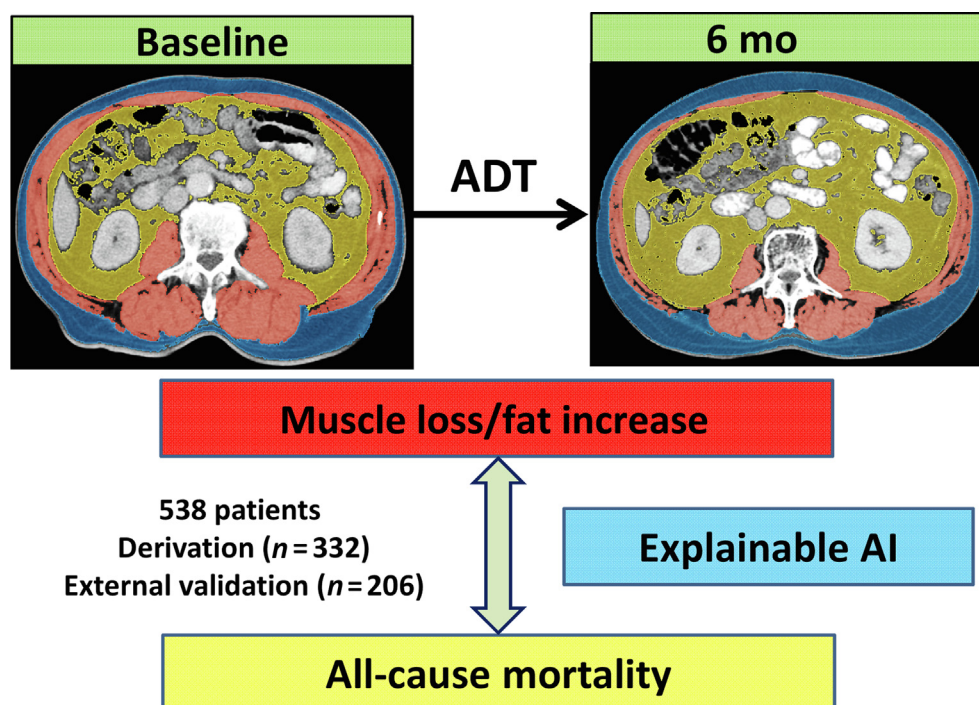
Utilization of explainable AI to explore the threshold of body composition change for all-cause mortality during androgen deprivation therapy. Body composition was assessed on a transversal computed tomography slice at the level of L3. ADT = androgen deprivation therapy; AI = artificial intelligence.
